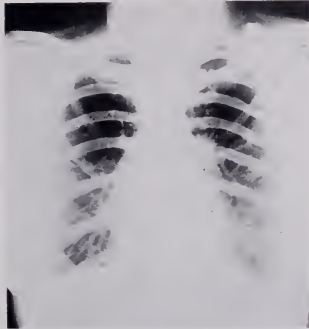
Patient M. M. Roentgenogram of the chest showing atelectasis with infiltration of the medial portion of the right lower lobe and a nodular infiltration in the region of the right hilus.
